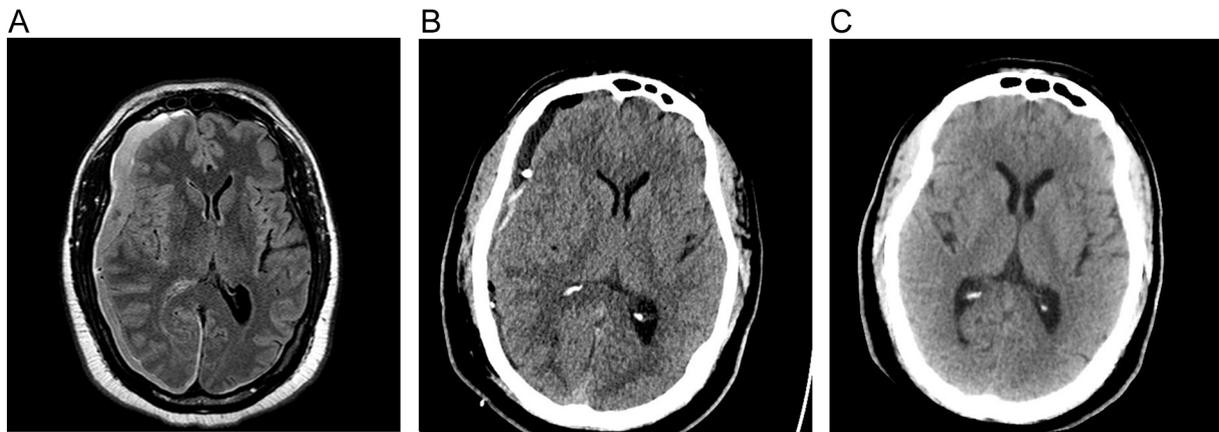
Imaging from case 1. A: Pre-operative MR (FLAIR) demonstrating right subdural collection with mass effect and midline shift. B: Post-operative CT demonstrating the presence of the SDD. Decreased size of the subdural collection and decreased mass effect. A small amount of pneumocephalus is present anteriorly. C: 1-month follow-up CT demonstrating resolution of the SDH.
